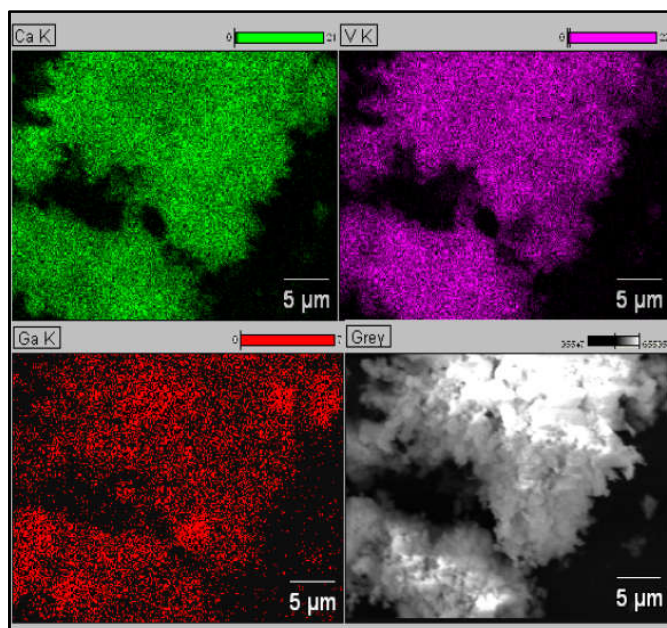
Elemental content and distribution of calcium vanadium and gallium mapped by energy dispersive X-ray analysis
